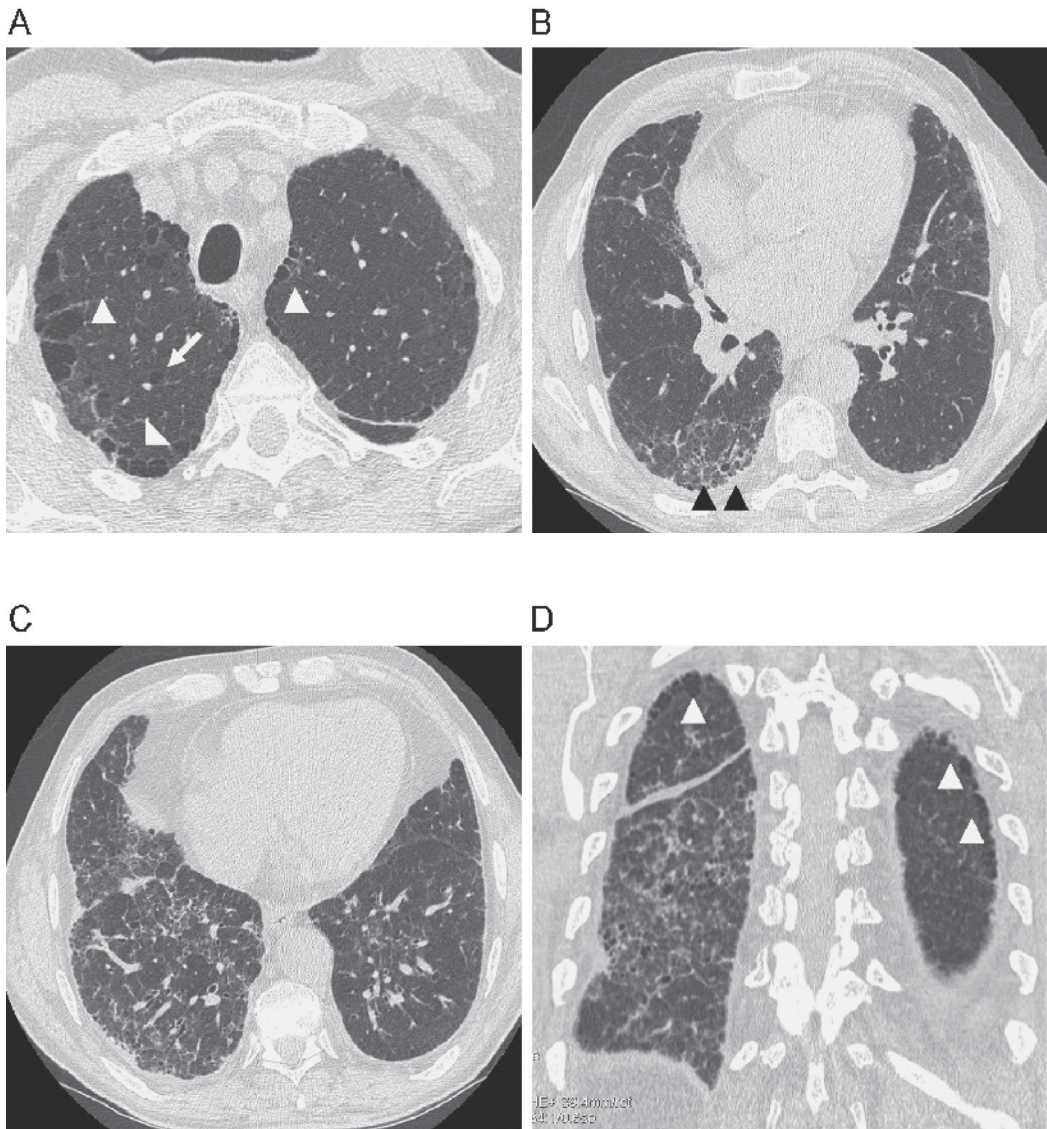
High resolution computerized tomography (HRCT) of the same patient. A) Presence of paraseptal emphysema and subpleural bullae (white arrowheads) and centrilobular emphysema (arrows) in both upper lobes. B) Reticular interstitial disease with intralobular thickening and images of subpleural honeycombing and traction bronchiectasis (black arrowheads) C) Reticular interstitial disease in middle and right lower lobes, with interlobular septal thickening, subpleural honeycombing and traction bronchiectasis. D) Coronal reconstruction in the posterior regions of both lungs: Bilateral paraseptal emphysema (white arrowheads) and reticular interstitial disease and honeycombing in right lower lobe. (Used with permission MD Portillo)
